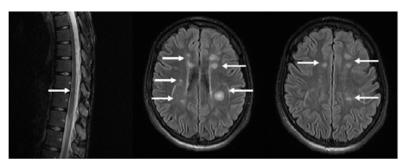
MRI of the neuroaxis with contrast. T2-weighted sequence with multiple hyperintense periventricular and pericallosal lesions, as well as lesion at the level of the T10 and T11 vertebrae (without contrast medium).
